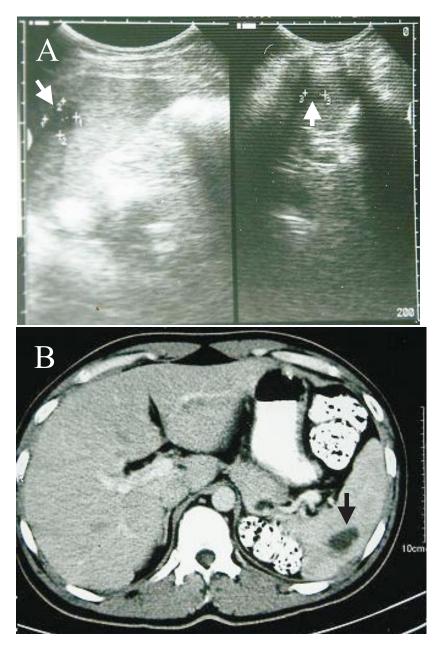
A, B. Ultrasound shows a large, regular hypoechoic lesion (arrow) located peripherally along the inferior aspect of the spleen (A). Contrast enhanced CT (CECT) from the same patient reveals a large irregular hypodense lesion (arrow) in the inferior aspect of the spleen suggestive of an abscess (B).
